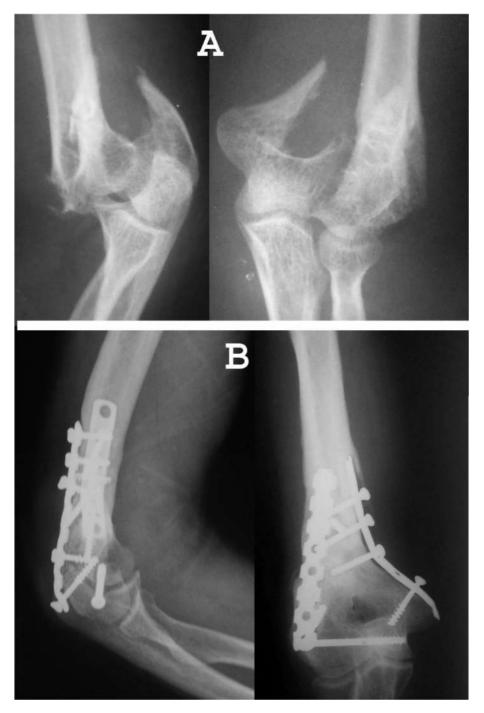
A-Case 1- Pre-operative Xray showing intercondylar fracture humerus. B-Case 1- TRAP; Follow up Xray picture showing union at fracture site.
